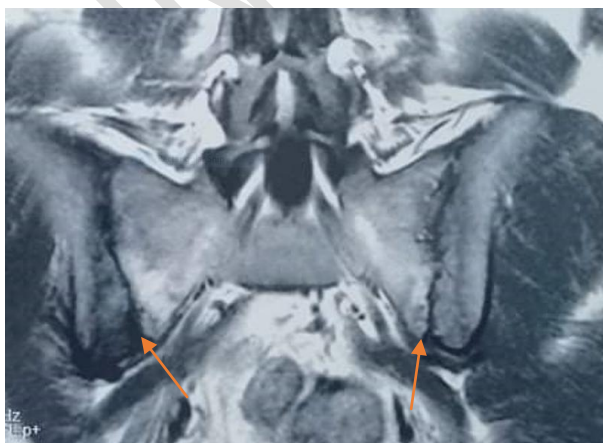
Sacroiliac joints MRI showing a bilateral active sacroiliitis (arrow)
